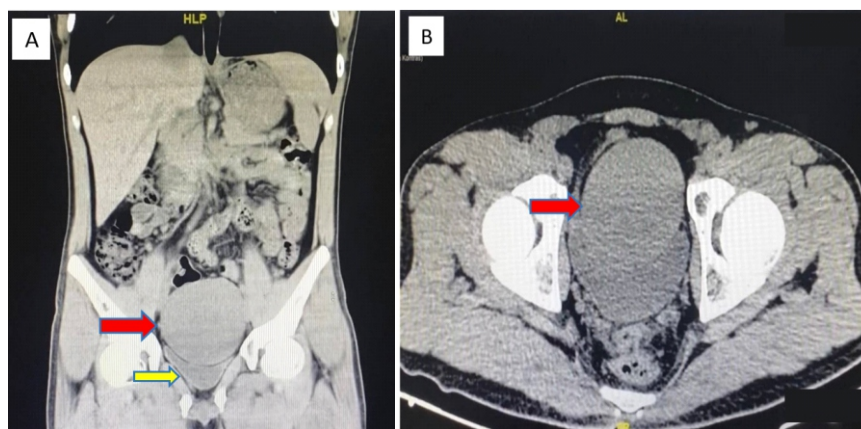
Abdomen computed tomography scan examination without contrast showed an intra-abdominal mass lesion (red arrow which presses the bladder to the inferior (yellow arrow) sized 11 x 7 cm; A) axial view; B) coronal view.
